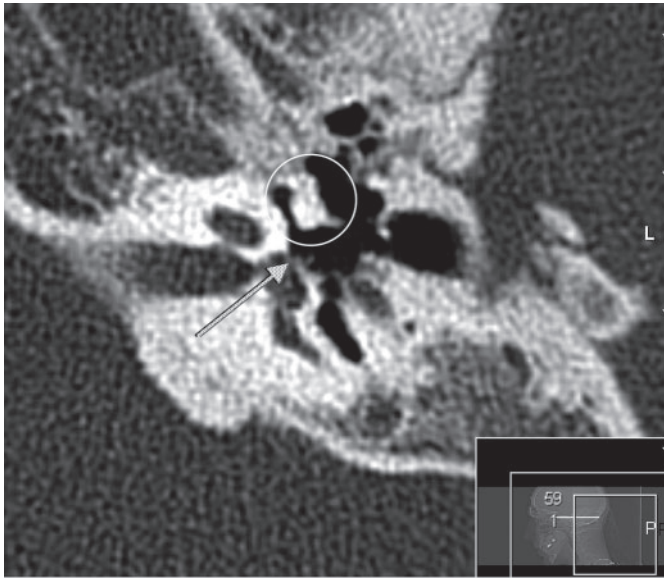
Preoperative CT scan with empty oval window niche (arrow) and incus/malleus complex (circle).
